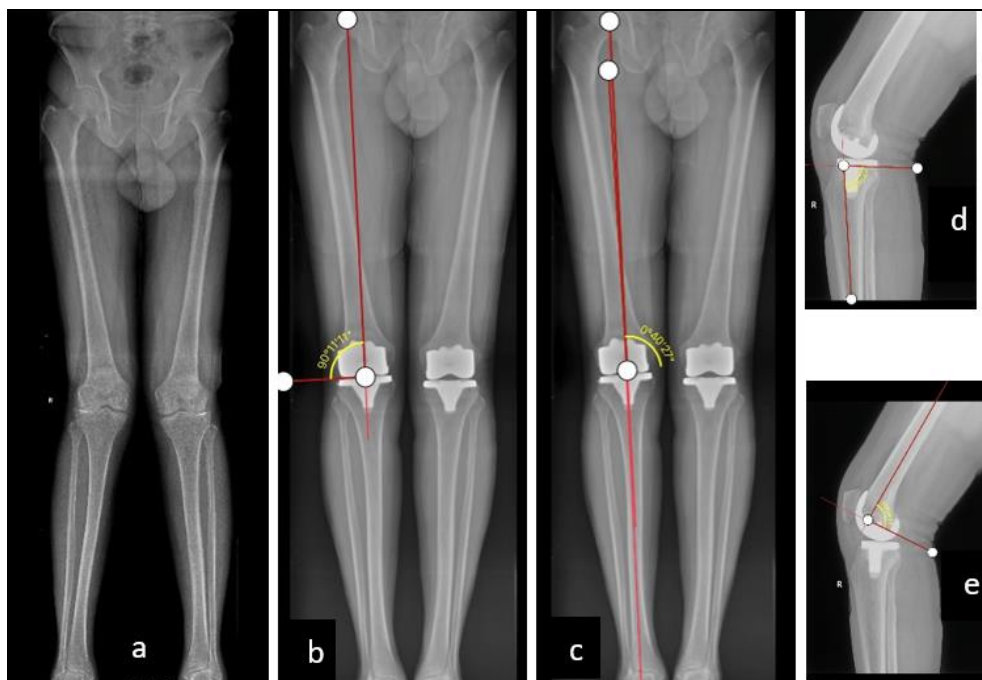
a) Scanogram of a bilateral secondary OA case, (b) Post-op radiograph showing mechanical axis of right femur, (c) post-op radiograph showing femoral-tibial angle of right lower limb (d & e) sagittal alignment of femur and tibia (right lower limb) post-op radiographs.
